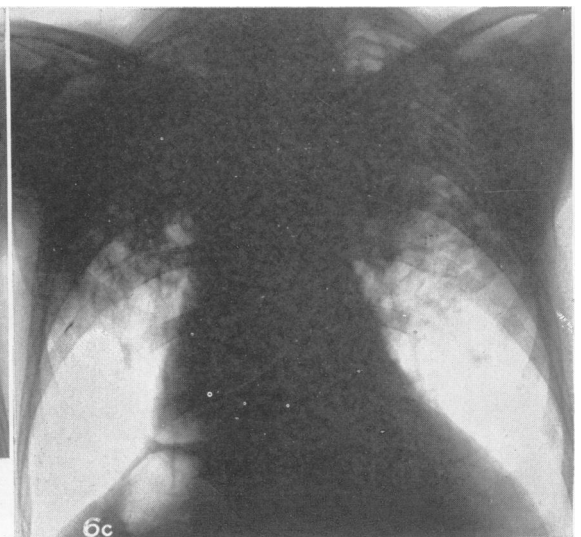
Case 7. Radiograph taken November, 1946
